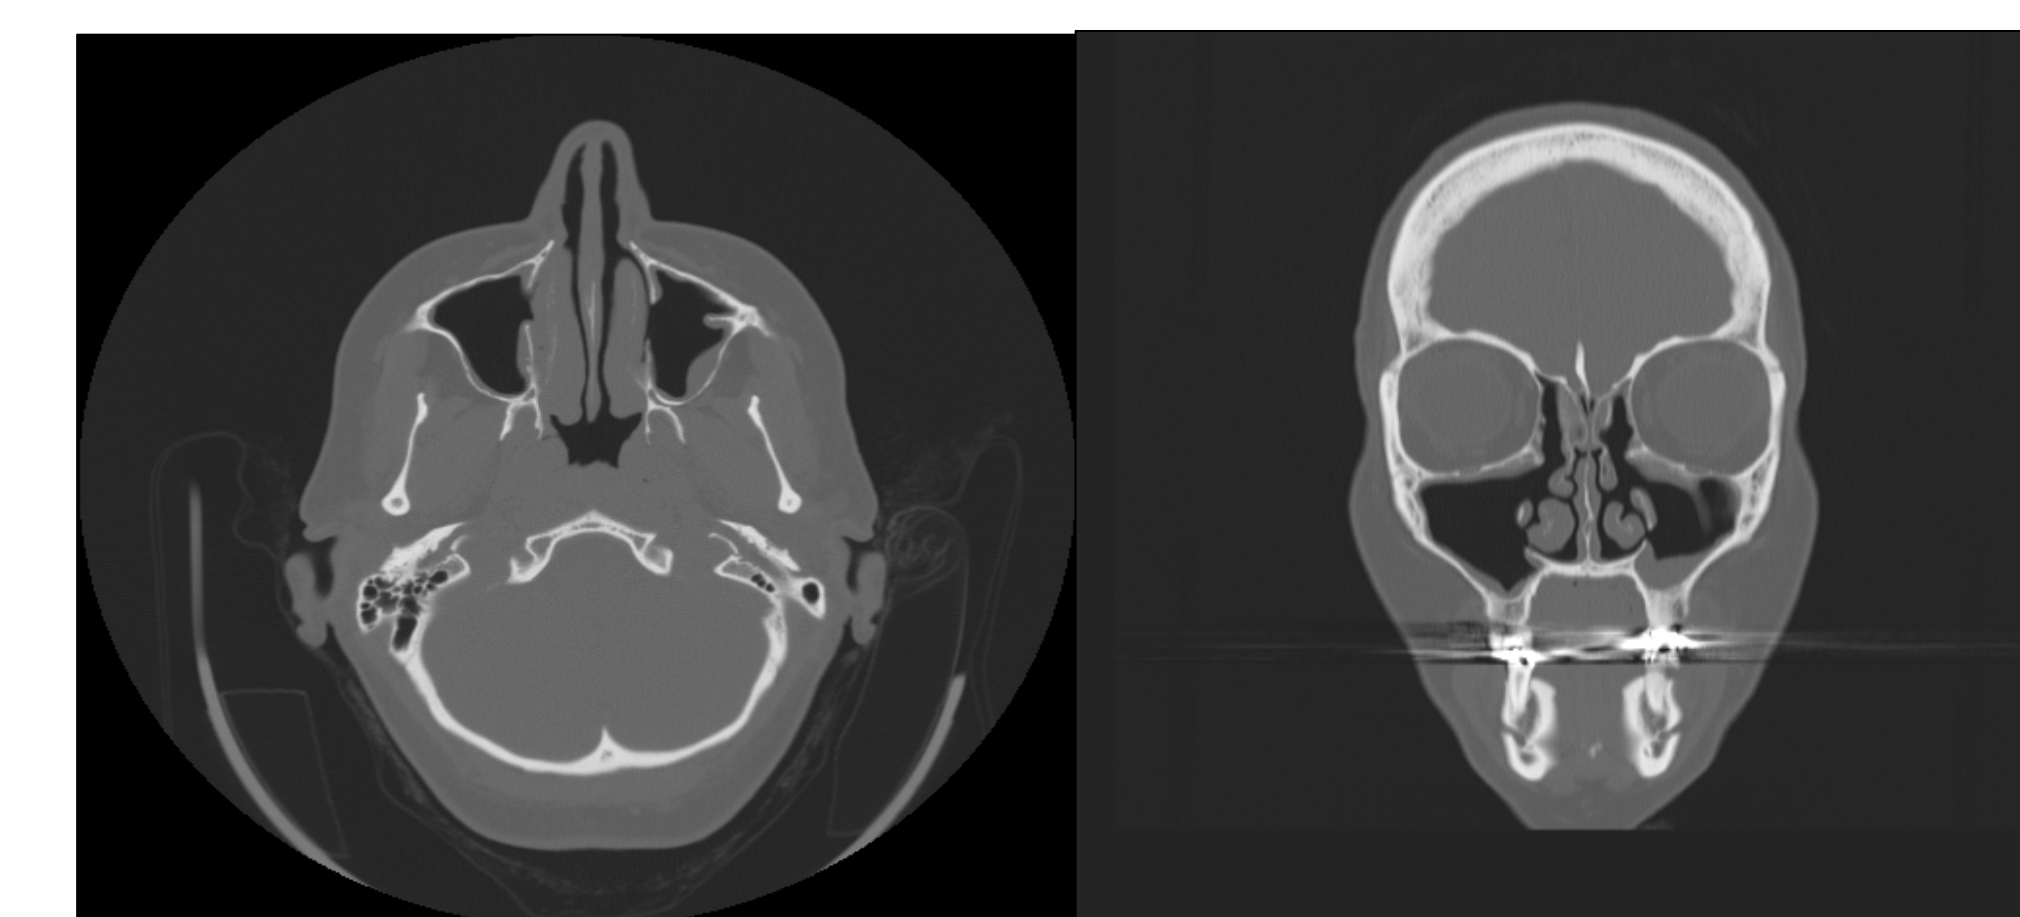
Post-operative sinus CT scans.
